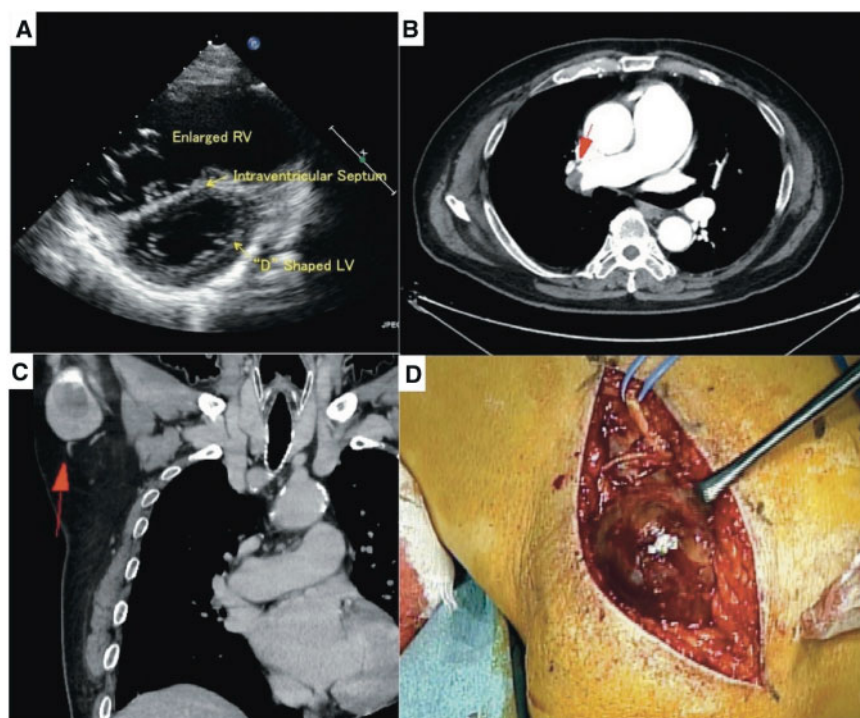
(A) Echocardiography on admission revealed that remarkably enlarged right ventricular suppressed left ventricular contraction. (B) Pulmonary embolism detected by contrast computed tomography scan on admission (arrow). (C) Huge thrombus located in the dilated right axillary vein (arrow). (D) Snap shot during surgery reveals that dark red thrombus existed inside the dilated vein.
